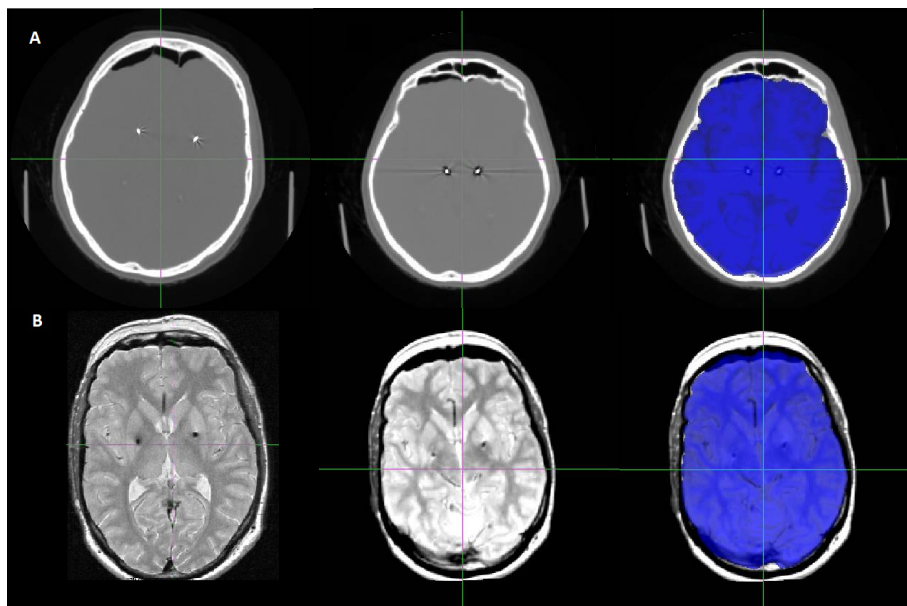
Co-registration of (A) CT with T1 datasets and (B) T2 with T1 datasets. (Left) Original CT and T2 images; (Center) CT and T2 images aligned with T1 using FLIRT; (Right) Fusion of CT or T2 images with T1, which is displayed in blue.
